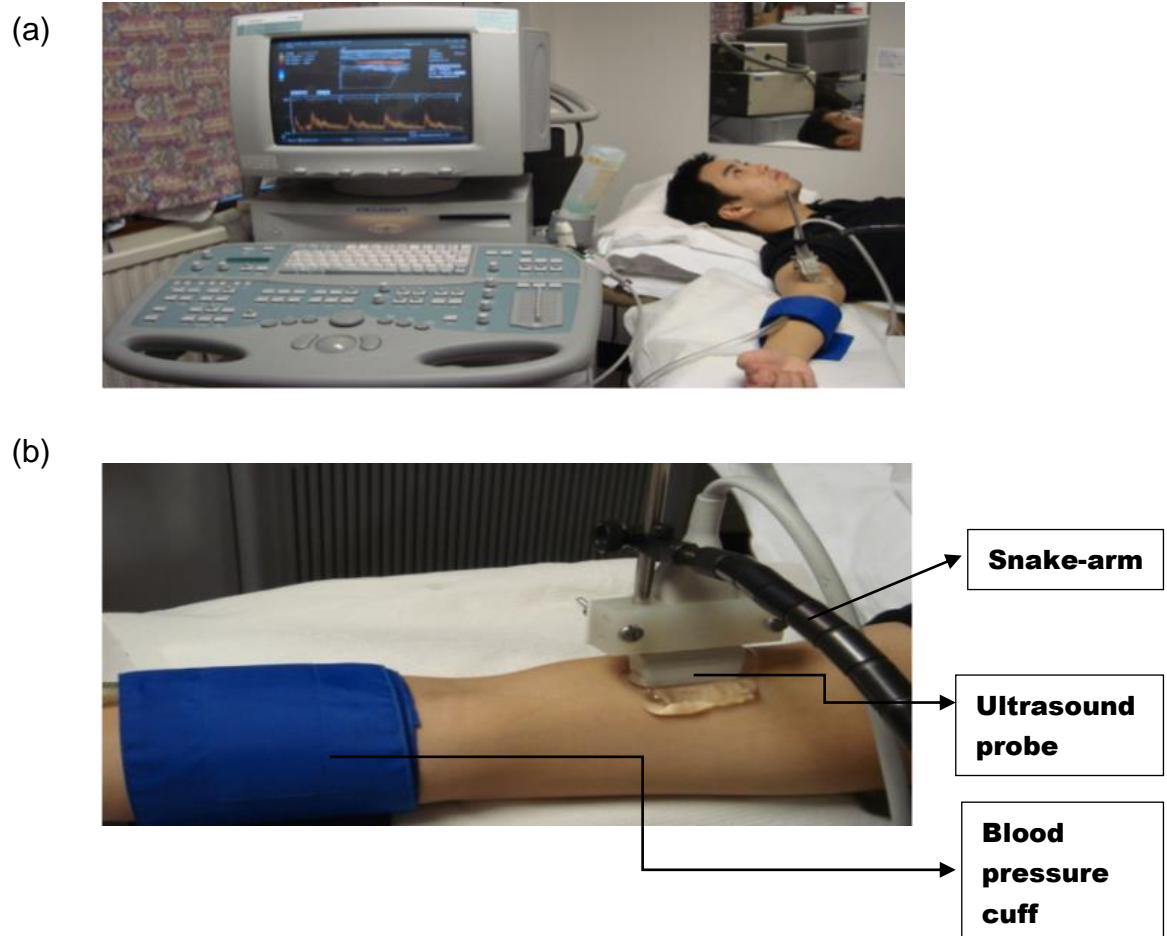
(a) Brachial artery FMD in the research set up. (b) A close up view of the placement of the ultrasound probe and the blood pressure cuff on a subject's arm.
